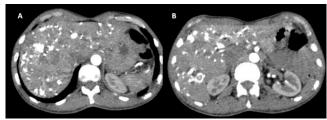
Multiple calcified, solid metastatic mass lesions in the liver on chest angiography CT sections that go through the abdominal level (a, b)
